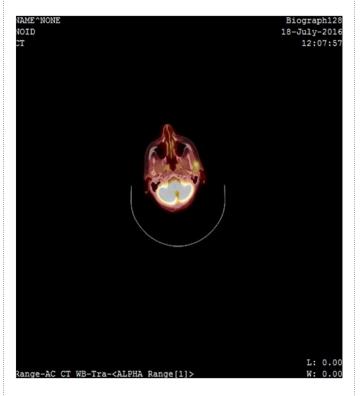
PET-FDG scan-Marked focus of FDG uptake seen in the left parotid which should be consistent with known possible metastasis.
